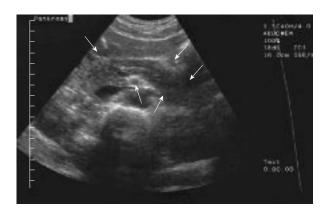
Transabdominal ultrasound depicting a pancreas (arrows) of normal size with slightly enhanced echogenicity.
